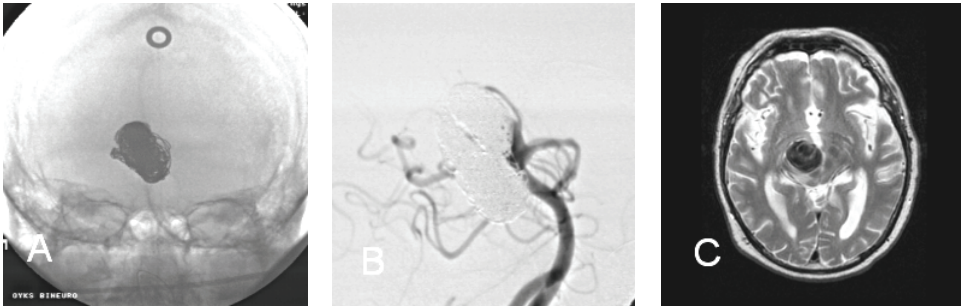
A giant BA aneurysm was coiled in a 68-year-old male with ischemic symptoms probably due to embolies originating from the aneurysm. The patient underwent endovascular treatment of the aneurysm, and due to coil compaction, two retreatments were performed. The angiogram after the last treatment demonstrates a large coil mesh (A) and a small neck remnant (B). After the last treatment, the patient had new symptoms due to an increased mass effect. MRI showed that the size of the aneurysm had increased to 30mm (initially 25mm), and the aneurysm was compressing the midbrain (C).
